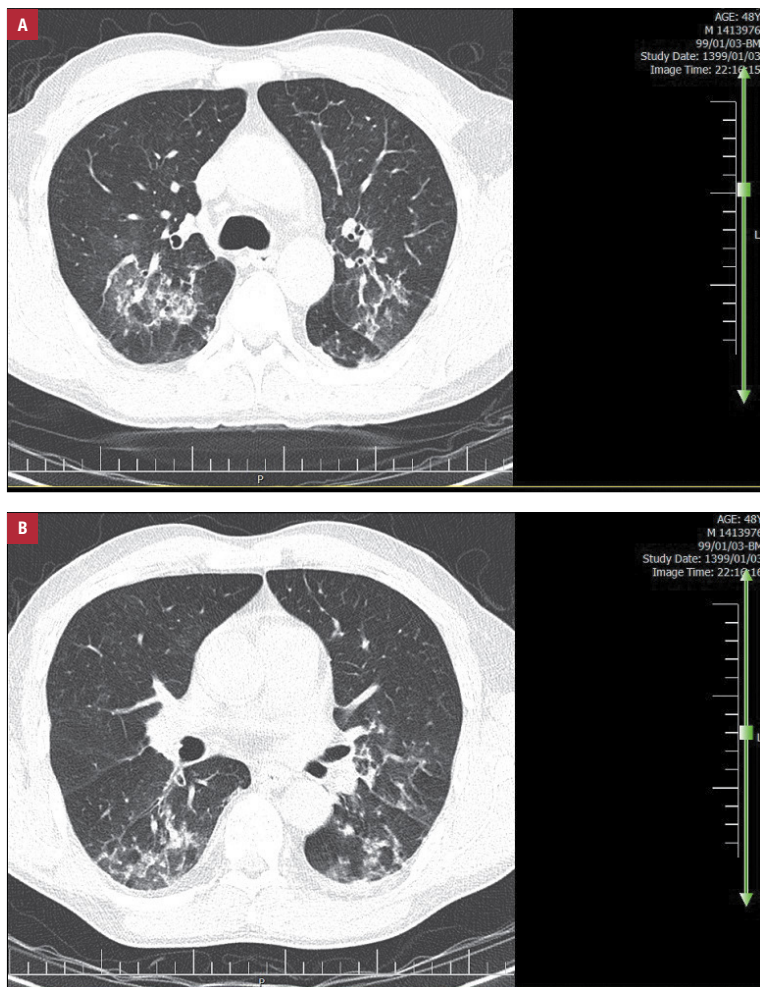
Spiral chest computed tomography findings in a patient with confirmed coronavirus disease 2019 who died during hospitalization: ground-glass opacities suggestive of coronavirus disease 2019 in upper (A) and middle lung lobes (B)
